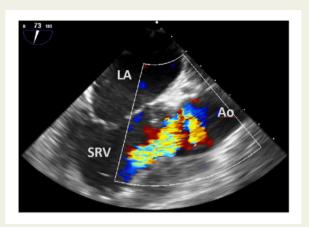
Figure I Baseline transoesophageal echocardiography, long-axis view. Severe eccentric aortic regurgitation. Ao, aorta; LA, left atrium; SRV, systemic right ventricle.
